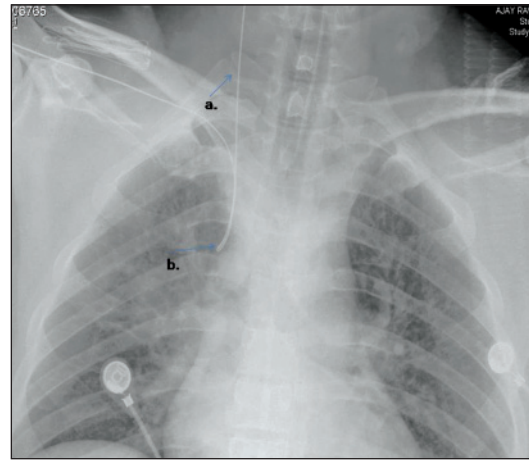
Portable chest X-ray showing looping of the guidewire a. into internal jugular vein b. superior vena cava
